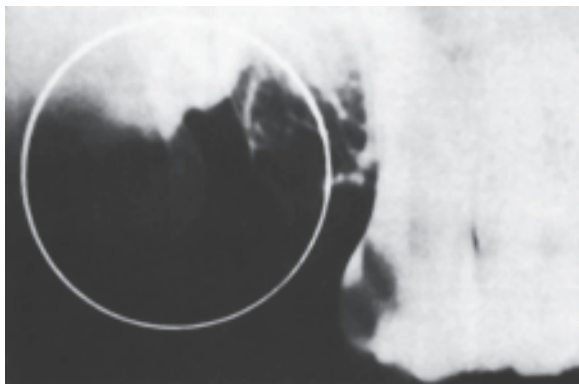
Radiograph showing radiopaque bulge of maxillary tuberosity
